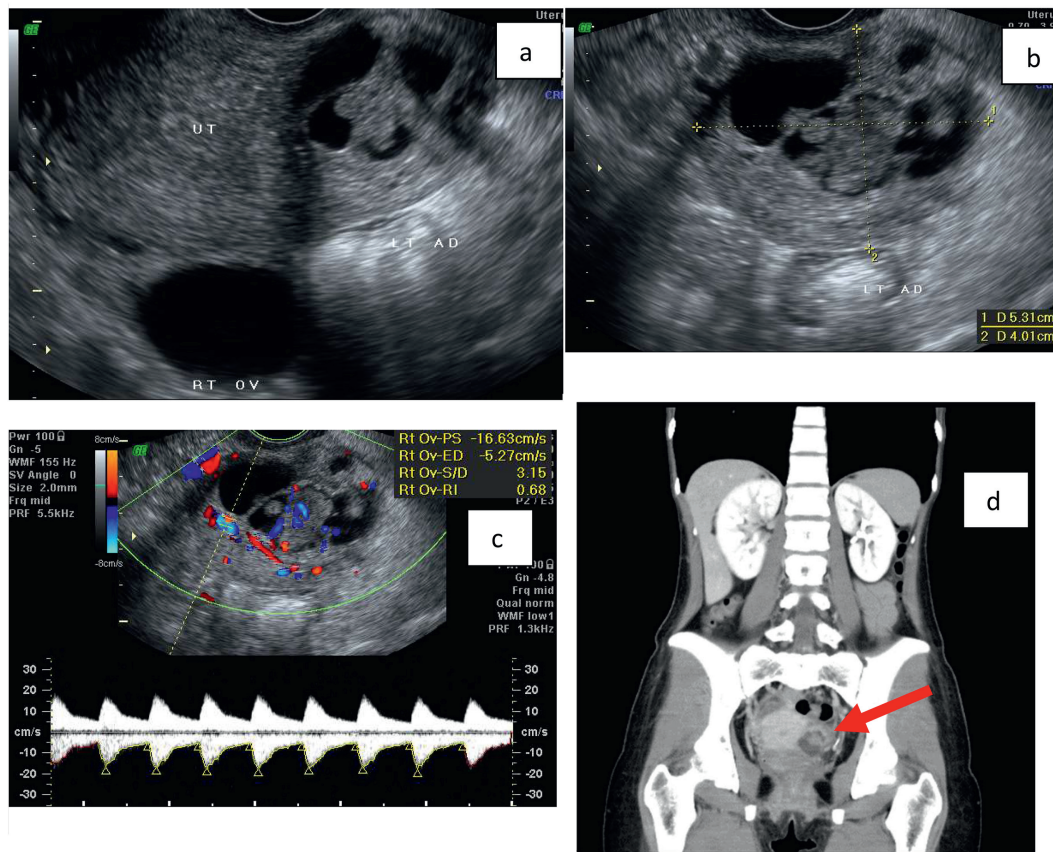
Recurrent mass was suspected during follow up under image studies. (a)transvaginal ultrasonography revealed the left pelvic mass close to uterus with thick wall; (b) low-echogenic content inside the left pelvic mass; (c)resistive index was 0.68 of the solid component inside the left pelvic mass; (d)coronal view of computed tomography of pelvis and abdomen of the left pelvic mass (red arrow).
